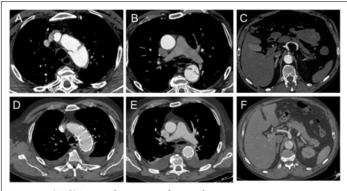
(A-C)Acute thoracic endovascular aortic repair in a patient with type B acute aortic dissection with collapsed true lumen and visceral malperfusion. (D-F)Control CT scan after TEVAR showing true lumen re-expansion.
